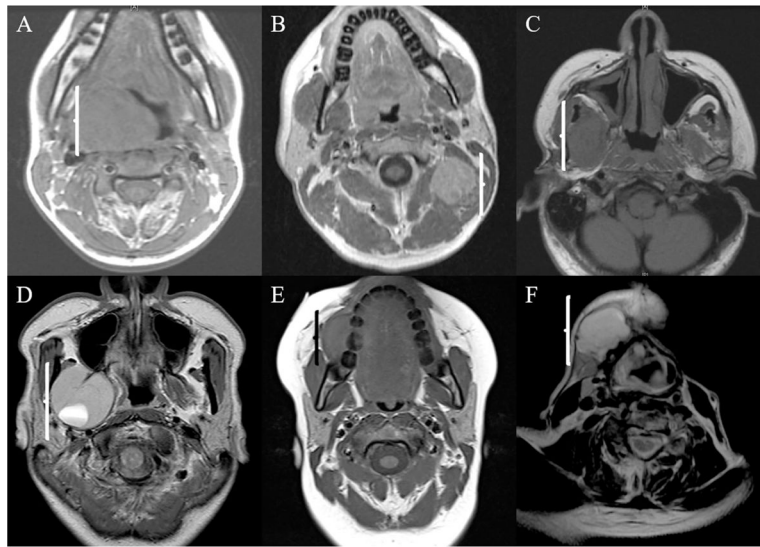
MRI findings of SS-HN. (A) pharynx, 17-yr old female, developed DR to the lung, deceased at 41 months, (B) posterior neck, 38-yr old male, alive at 146 months, (C) infratemporal fossa, 29-yr old female, developed LR and DR to the lung, alive at 129 months, (D) infratemporal fossa, 32-yr old female, developed LR, alive at 101 months, (E) buccal mucosa, 13-yr old female, alive at 64 months, (F) submandibular region, 54-yr old male, developed LR and DR to the lung, deceased at 95 months.
